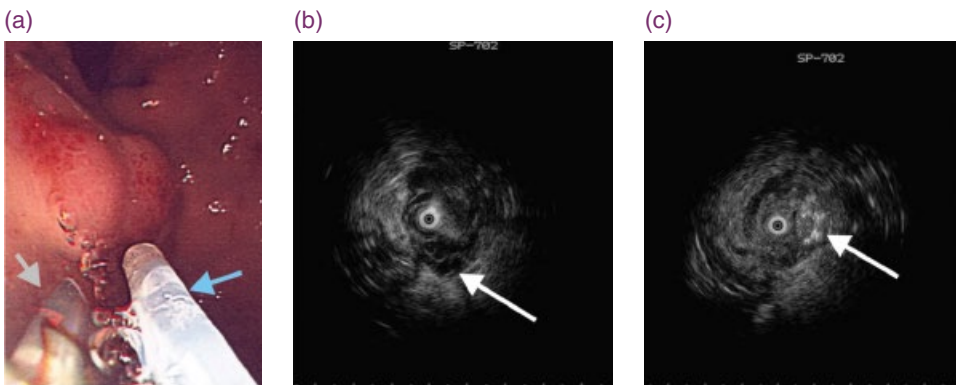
(a) Injection of thrombin for variceal obliteration using an endoscopic ultrasound miniprobe (grey arrow) and an injection needle (blue arrow). (b) Appearance of varices under a 12 MHz miniprobe (white arrow). (c) "Snow storm" appearance of an obliterated area of a varix (white arrow) following thrombin injection.
